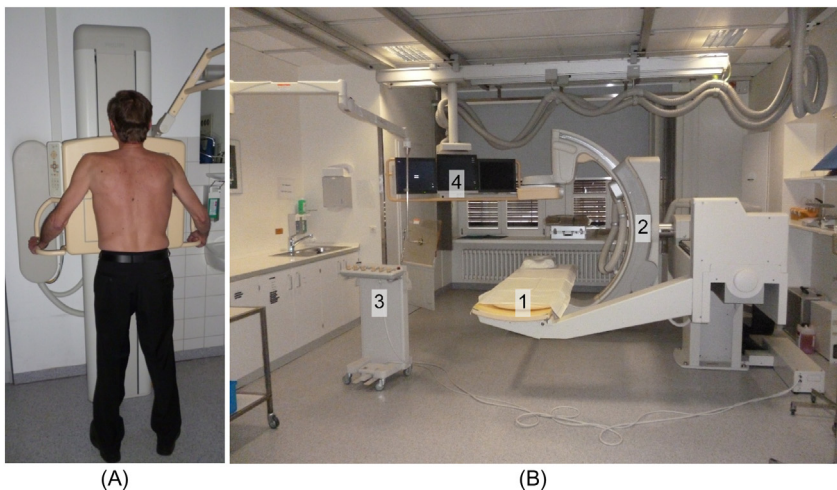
(A) Plain X-ray of the thorax. The X-ray source on the right side (not visible). The patient is positioned against the flat detector (posterior–anterior X-ray); (B) conventional dynamic fluoroscopy suite: 1, stretcher; 2, C-arm; 3, steering unit; 4, video screens. The patient's bed and the C-arm can be moved in all required degrees of freedom independently of each other. *All from MITI.*
